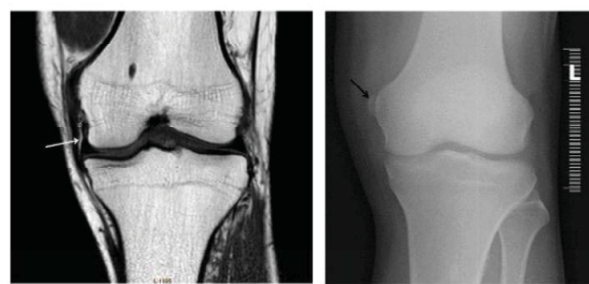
(a) MRI of 26 year old male patient showing medial collateral ligament injury (arrow), whereas the corresponding plain radiograph (b) showing calcification at the attachment of MCL to the medial femoral condyle (Pellagrini steida syndrome) Fig. 3(b) The plain radiograph of 26 year old male patient showing calcification at the attachment of MCL to the medial femoral condyle
